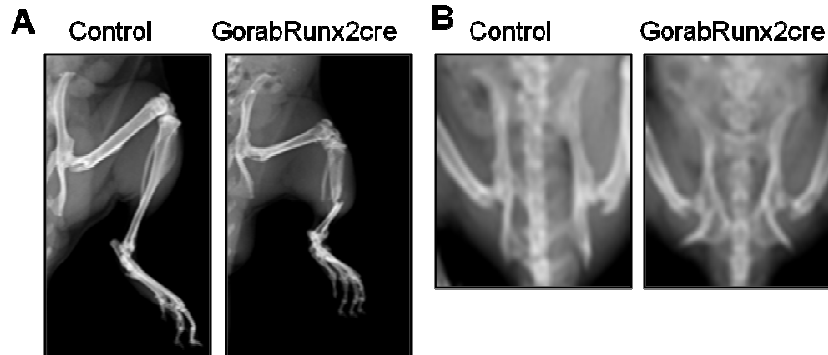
X-ray Radiography (A) Low degree of mineralization in GorabRunx2cre mutants compared to their littermate controls. The severe thinning of the bone leads to a higher fracture risk especially between 2 weeks and 6 weeks. (B) Malformed pelvis in the mutant. Note the thinner and more bended bone structure.
